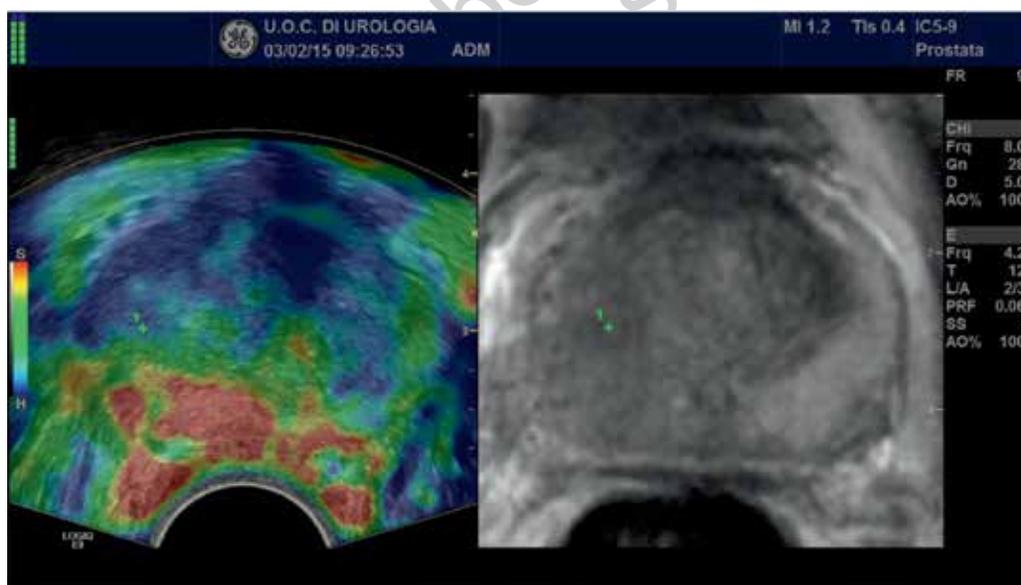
3.0 Tesla pelvic multiparametric MRI/TRUS fusion imaging (axial scan) (ACHIEVA 3.0 Tesla; Philips Healthcare Best, the Netherlands – Logiq E9 General Electric; Milwaukee, WI): multiparametric MRI/TRUS fusion procedure and the application of markers.
